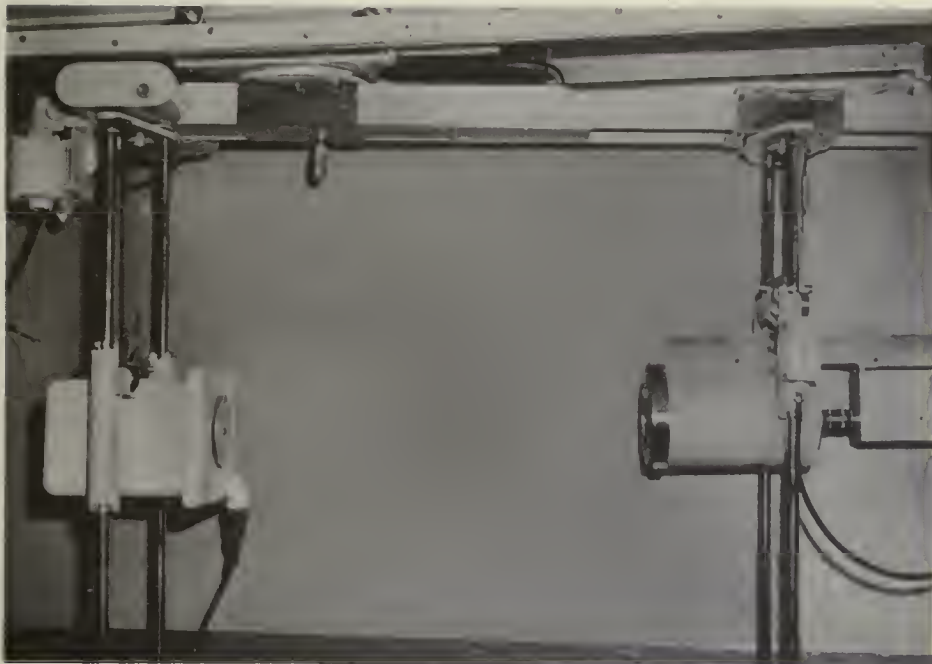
Overhead mounting showing the image tube—television system (right) and the X-ray machine (left) used in viewing the patient before and during therapy.
